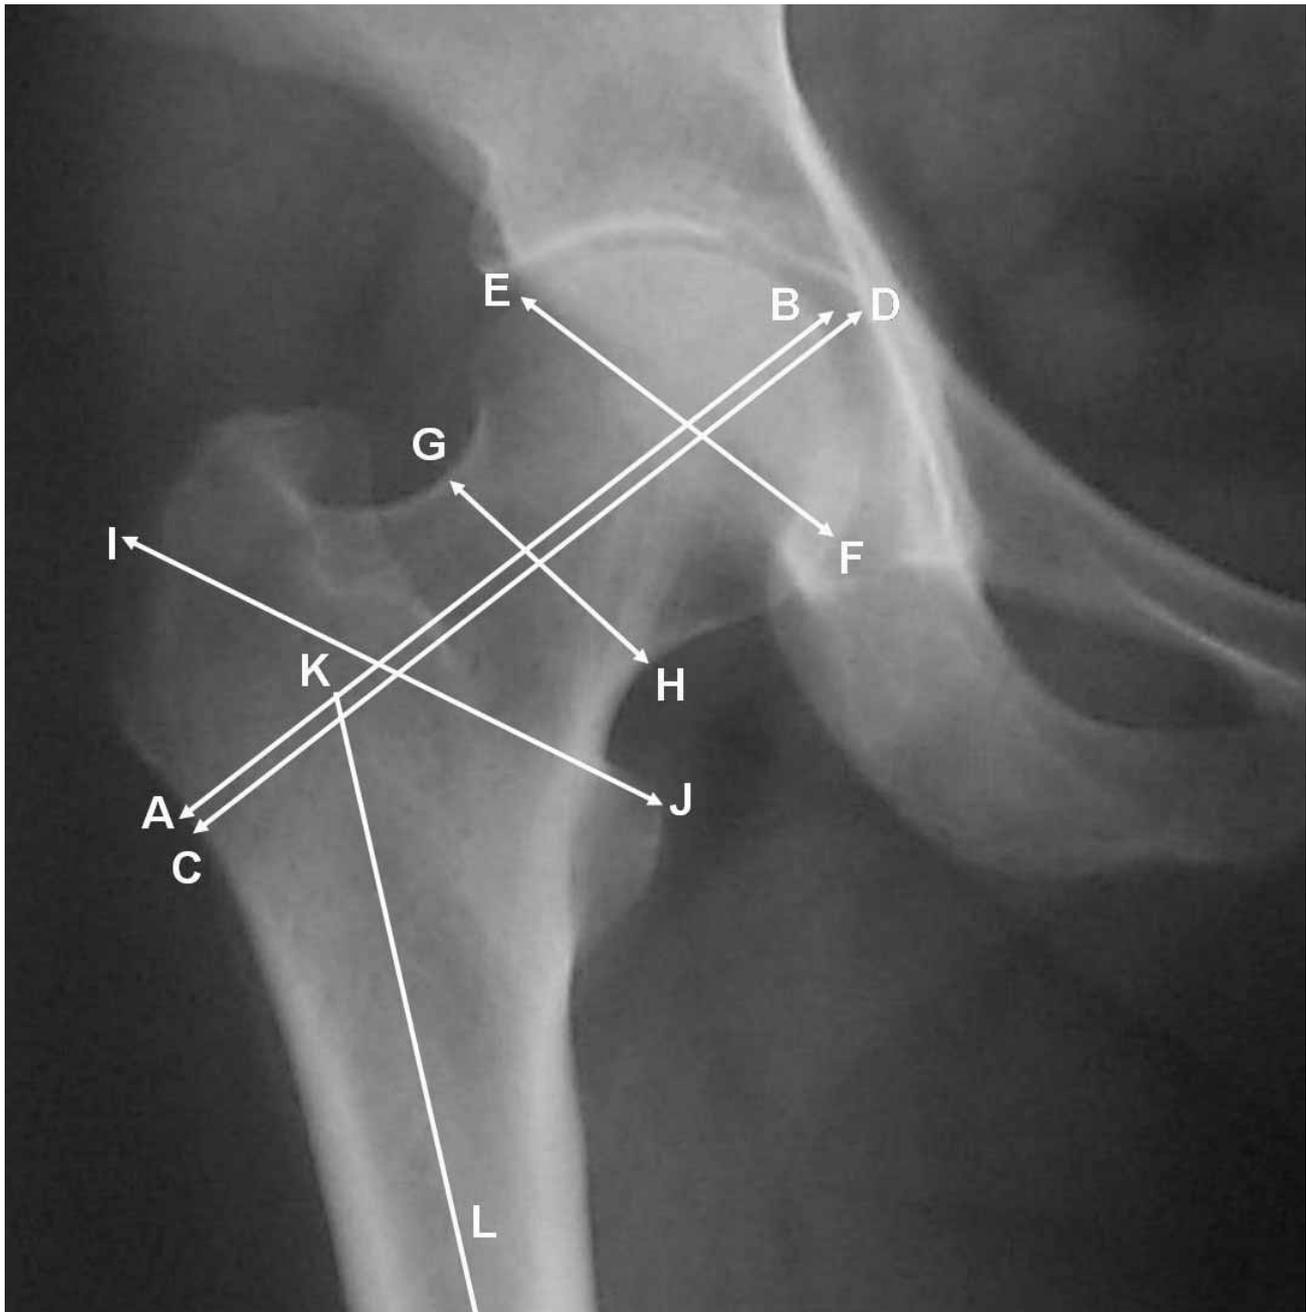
Definition of the parameters measured from the anteroposterior roentgenograms of the proximal femur. A-B (FAL): Length of the femoral neck axis from the base of the lateral part of the greater trochanter to the caput femoris; C-D (HAL): Length of the femoral neck axis from the base of the lateral part of the greater trochanter to the inner pelvic brim; E-F (HW): Broadest cross-section of the femoral head; G-H (FW): Narrowest cross-section of the femoral neck; I-J (TW): Cross-section from immediately above the lesser trochanter to the most lateral aspect of the greater trochanter; BKL (Q-angle): Angle between the femoral neck and shaft of femur.
